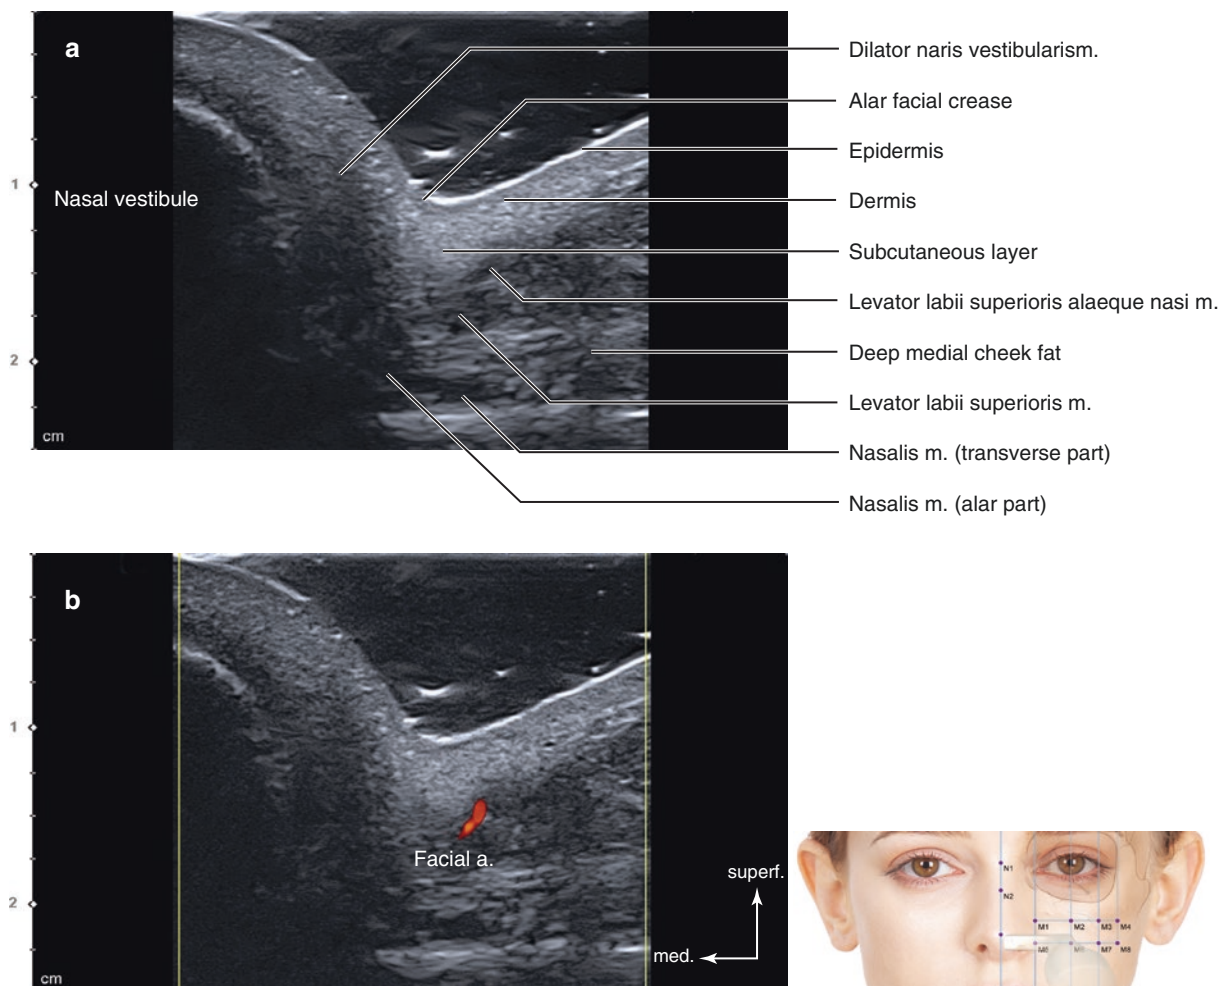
Ultrasonography on the intersection point of TL5 and PL1 (M5). (a) B mode (transverse view, 15 MHz by linear transducer), (b) Doppler mode (transverse view, 15 MHz by linear transducer), (c) B
